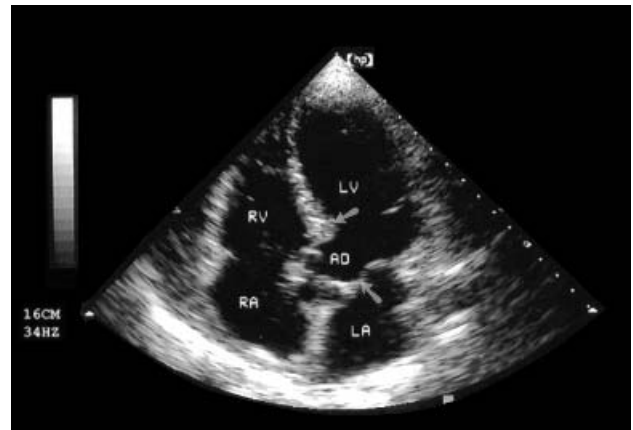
An apical “4 chamber with aorta” (AO) view of the heart by two-dimensional echocardiography of a 70-year-old asymptomatic subject. The thickness of the wall separating the right from the left ventricle and of the mitral valve leaflets is suggestive of a mild septal hypertrophy of the left ventricle (LV) and fibrosis of the valve (arrows). Compare Figure 2. LA, left atrium; RA, right atrium; RV, right ventricle (Figure courtesy of L.Targa, MD, Division of Cardiology, Este Hospital, Padova, Italy.)
